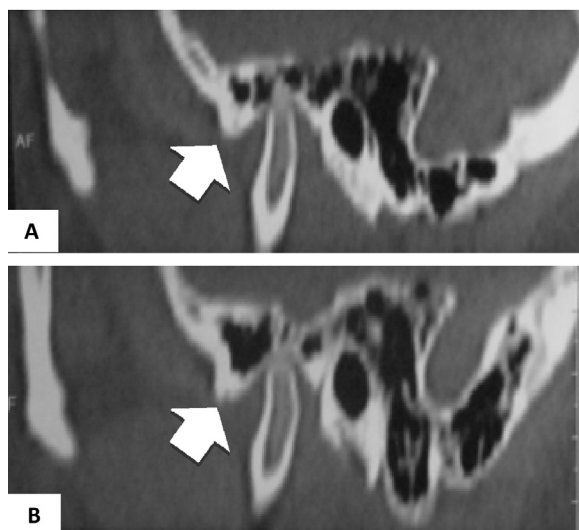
Case 2, computed tomography showing the pneumatization of the articular eminence (arrows); (A) right side and (B) left side.
